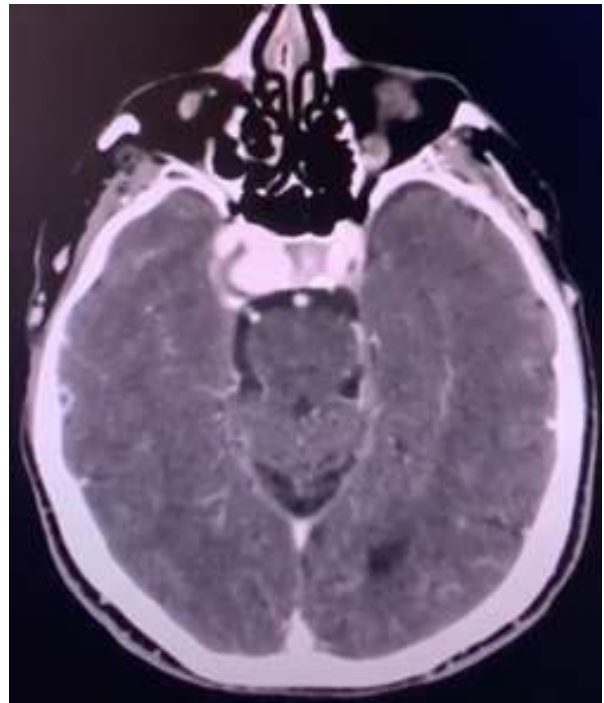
Brain CTA image demonstrating an 11x15x10mm internal carotid aneurysm in the right cavernous sinus.
